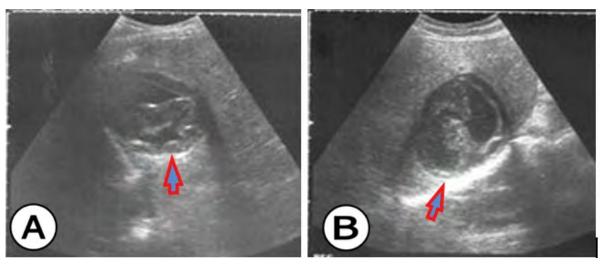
(A) The Ultrasound of the liver and (B) Ultrasound detection of inflamed hydatid cysts of the liver (arrow).
